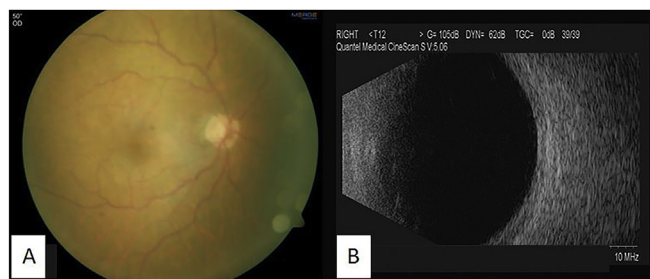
Clinical and ultrasound findings, three weeks after intensive treatment, showed no signs of intraocular inflammation, Visual acuity 20/60; A. clear fundus view, B. clear B-scan image.
